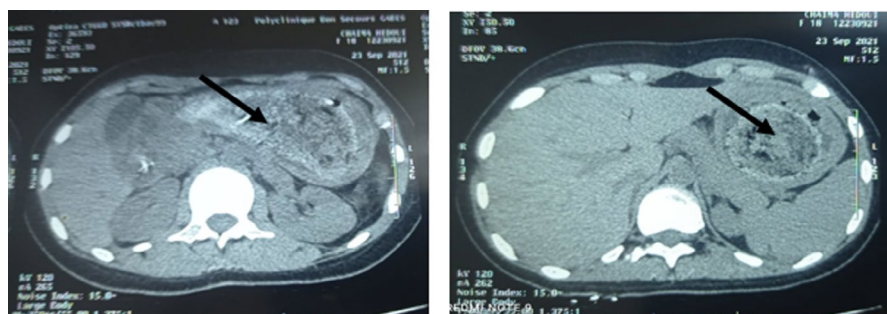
CT Scan showing trichobezoar (arrow) occupying the extent of the stomach
